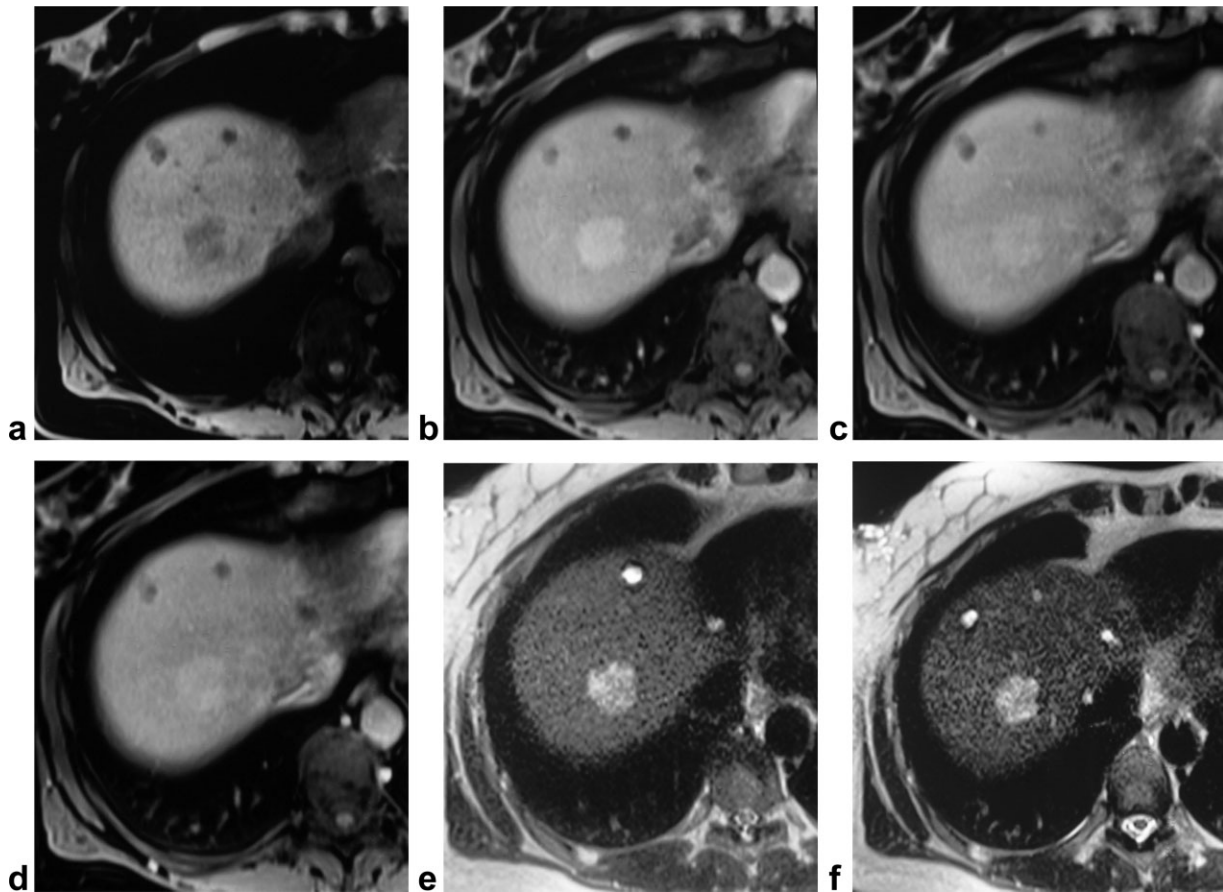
a-f: Hepatic adenoma. On the unenhanced T1-weighted VIBE acquisition (a) a nodule heterogeneously hypointense versus surrounding right liver lobe parenchyma, is detectable. After slow bolus Resovist administration nodule enhances in the arterial phase (b), without any appreciable wash-out during portal venous (c) and equilibrium phases (d). On the unenhanced HASTE T2-weighted sequence (e), the lesion appears hyperintense versus liver parenchyma, without any significant changes on the 10-min contrast-enhanced acquisition (f), at visual assessment. However, the quantitative analysis demonstrated a -33% signal loss of the nodule which appears still hyperintense due to a -53% signal loss of the surrounding parenchyma. Note, in all the images (a-f), some little cysts in the anterior portion of the liver parenchyma.
